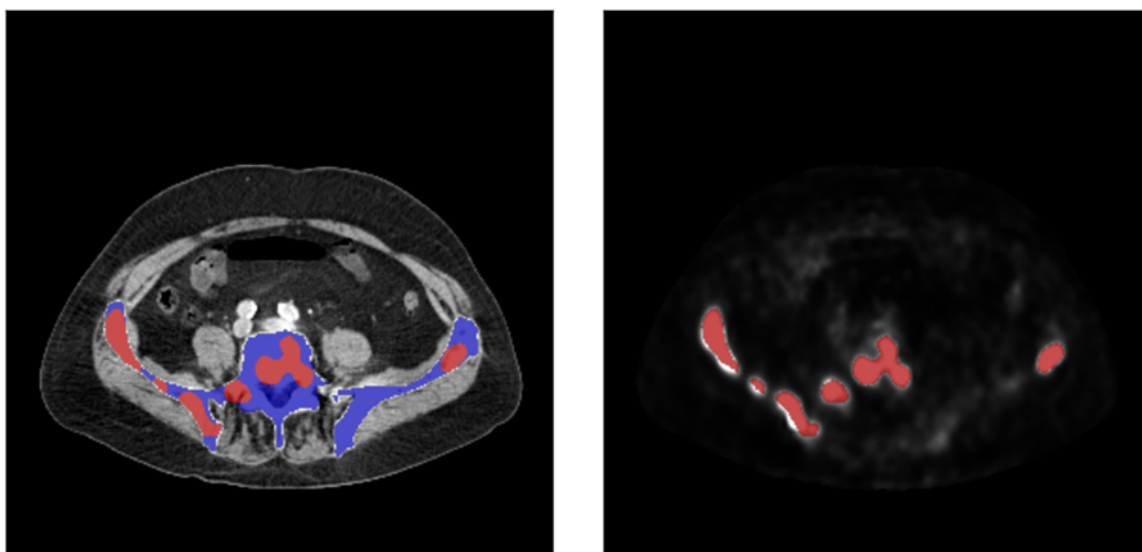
PET and CT image of one patient. The blue overlay shows the bone mask computed by the tool and the red overlay shows the tumour mask computed with a SUV-threshold of 3.
